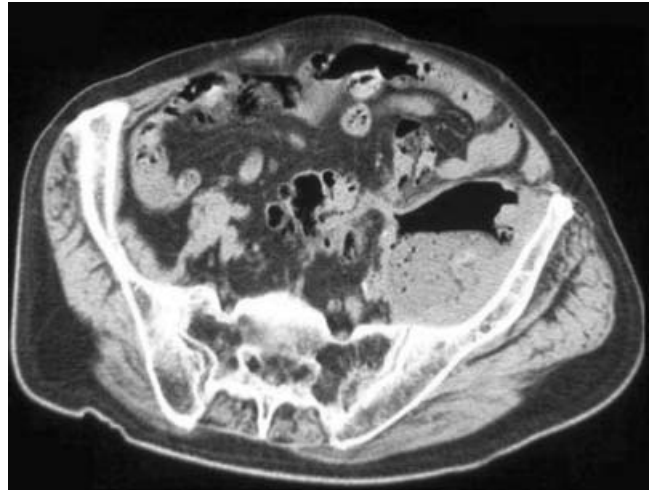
CT-Scan of the lower abdomen showing a Psoas abscess extending from the spine into the left groin, adjacent to reactive sigmoid colon (arrow).
